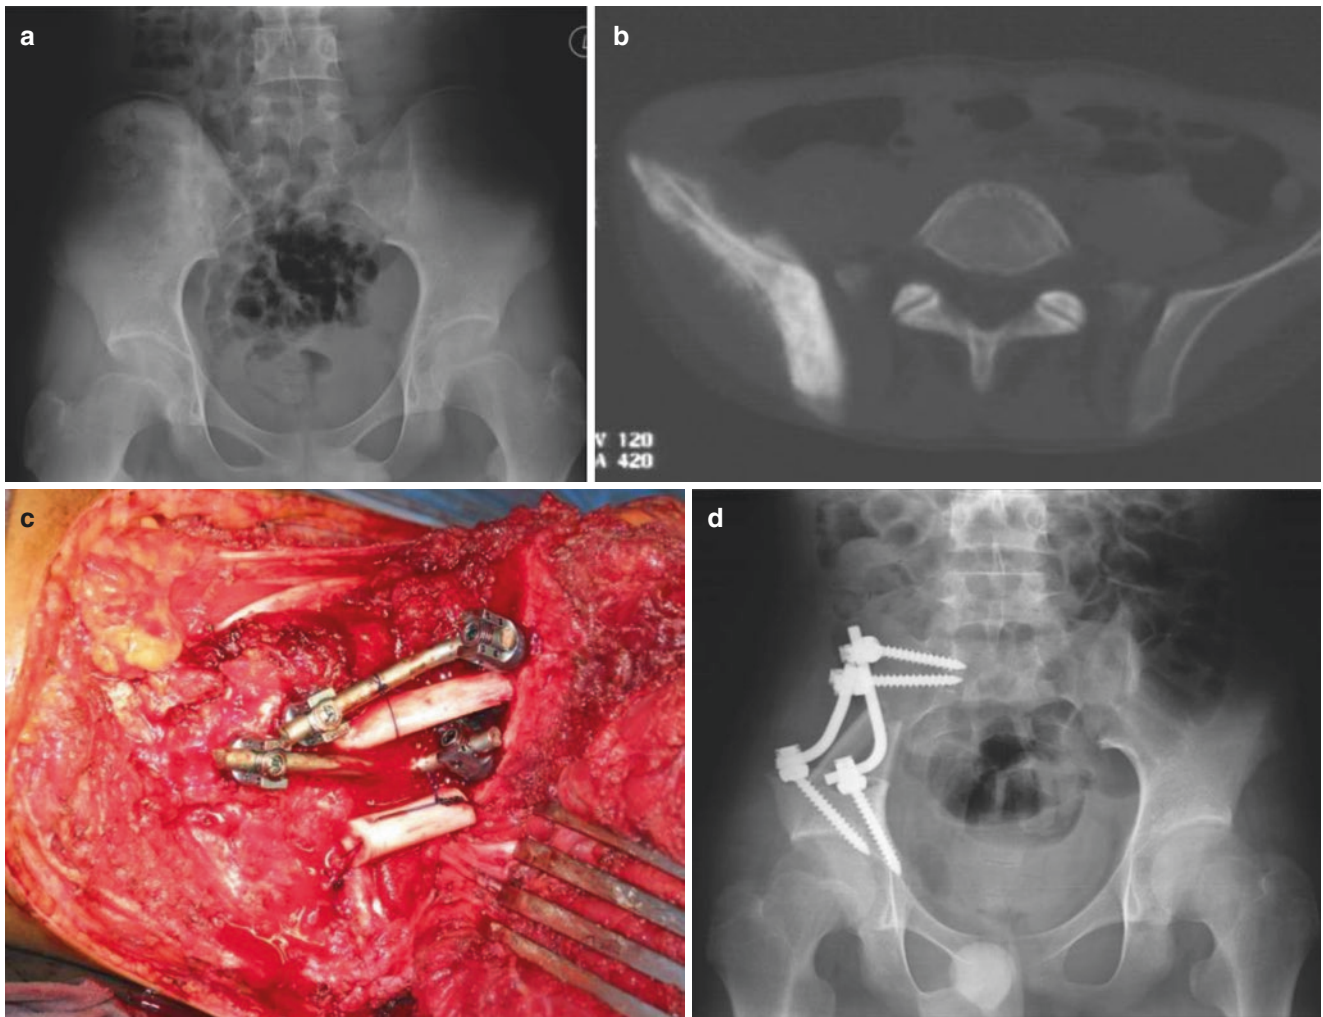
The patient was a 14-year-old male with Ewing's sarcoma of right pelvis. Preoperative X-ray (a) and CT scan (b) showed the lesion. (c) Intraoperative photograph showed fibular graft combined with screw-rod system being used for reconstruction. (d) Postoperative X-ray
